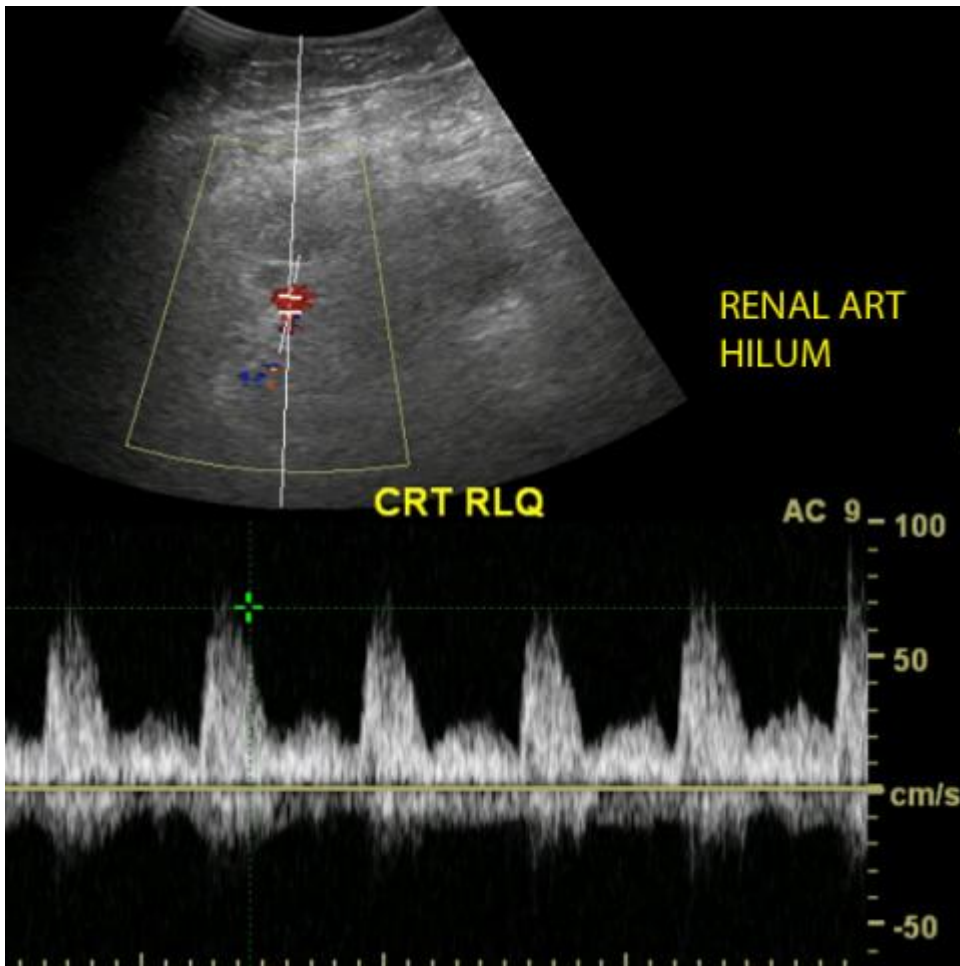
Normal renal artery shown on spectral Doppler ultrasound. There is a brisk systolic upstroke and antegrade diastolic flow in the normal renal artery waveform.
